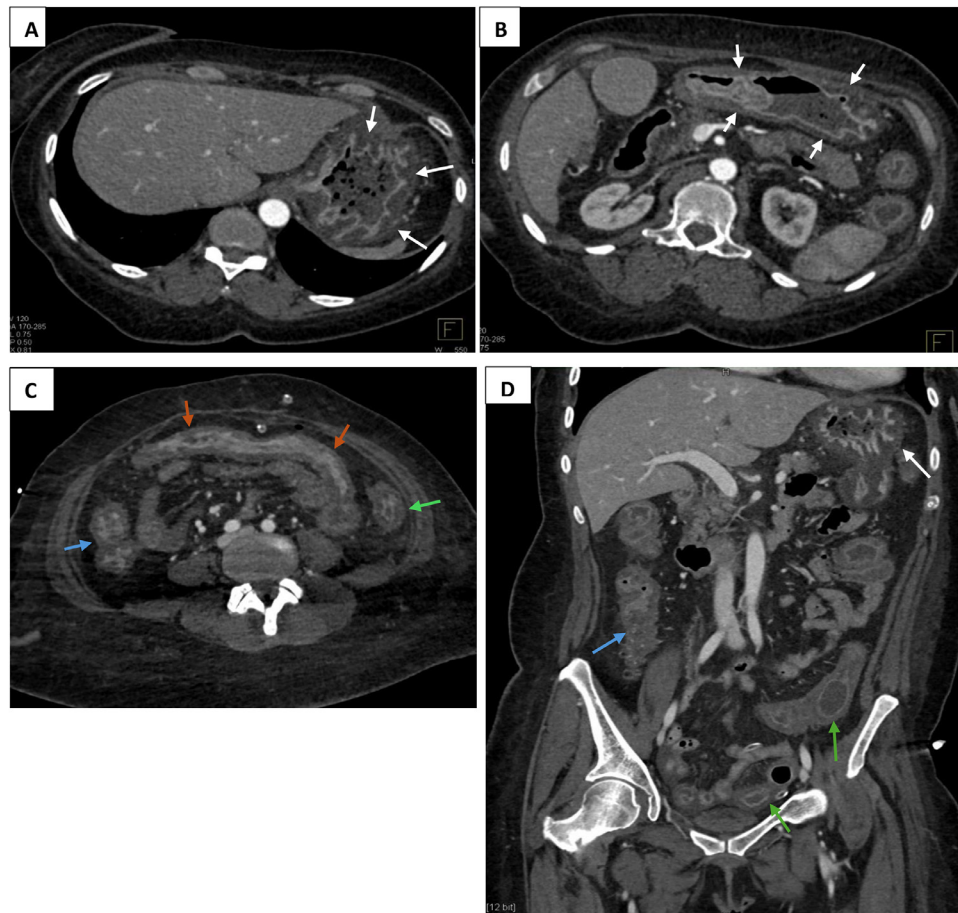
A 52-year-old female presenting with recurrent watery diarrhea. Contrast-enhanced axial CT scans show prominent thickening of the gastric folds in the gastric body (A - white arrows) and the antrum (B - white arrows). The patient has prominent enhancement of folds of the transverse colon (C - orange arrow), ascending colon (C - blue arrow) and descending colon (C - green arrow), in a pattern consistent with pancolitis. The small bowel shows no obstruction. Contrast-enhanced venous phase coronal CT scan demonstrates diffuse bowel wall thickening involving the stomach (D - white arrow), ascending colon (D - blue arrow), and descending colon down to the sigmoid (D - green arrow), depicting worsening pancolitis. No intraluminal contrast extravasation is seen to suggest an acute GI bleed.
